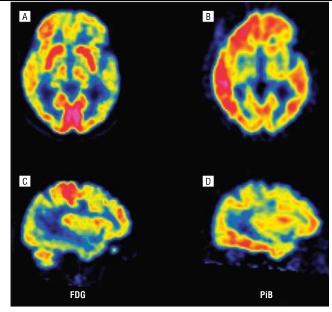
Positron emission tomography (PET) images from a 76-year-old patient with dementia. Fluorodeoxyglucose (FDG) and Pittsburgh Compound E (PiB) scans were performed within 3 years of each other. A and B, Positron emission tomography images from coregistered transaxial FDG (A) and PiB (B PET images at the level of the striatum. Red areas represent higher metabolism of FDG and higher PiB retention. There is diffuse hypometabolism and PiB retention in frontal and temporal cortices. Regions with relatively normal metabolism, such as striata and medial occipital cortex, demonstrate relatively less PiB retention. Subject's left is at right. Evidence of the known subdural effusion occurring in the interval between FDG and PiB imaging is seen in the right frontal convexity of the PiB image. C and D, Coregistered left parasagittal FDG (C) and PiB (D) images at level of the insula. In this view, PiB retention is greatest in the inferior temporal gyrus, and there is relative sparing of the primary sensorimotor cortex where FDG uptake is highest.
